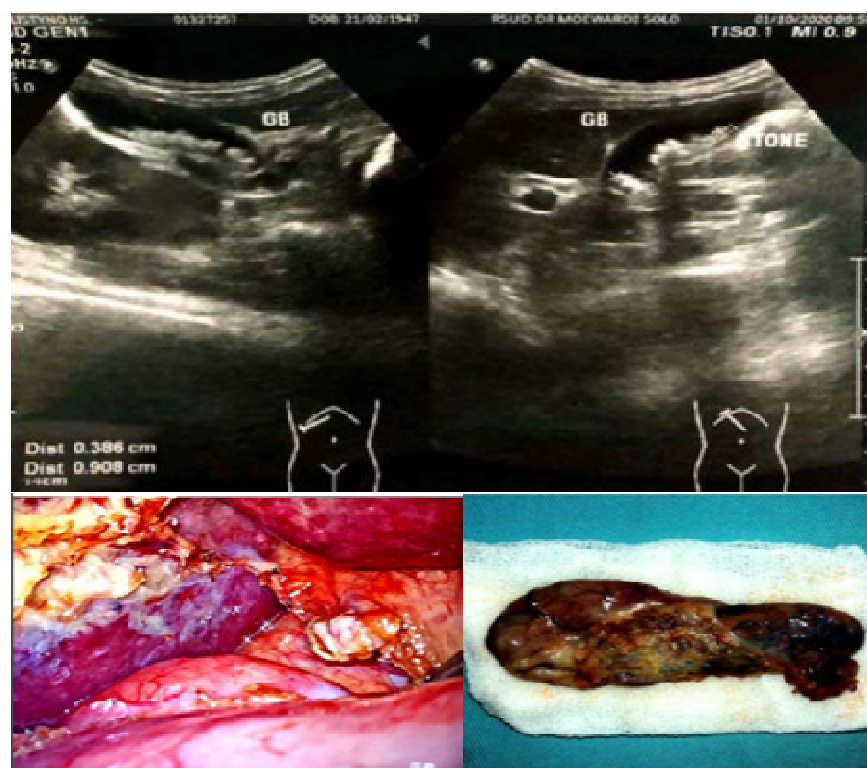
Ultrasound examination results b. Laparoscopic cholecystectomy, c. Clinical macroscopic vesicafellea
